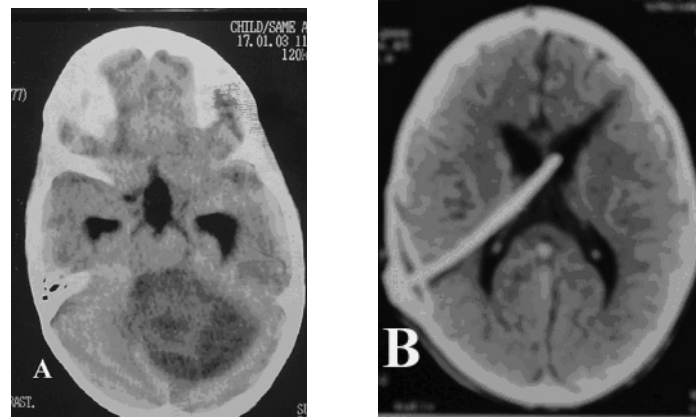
Non-contrast CT brain axial cut shows was: A: Posterior fossa midline intra-axial lesion causing obstructive hydrocephalus. B: After shunt insertion.
